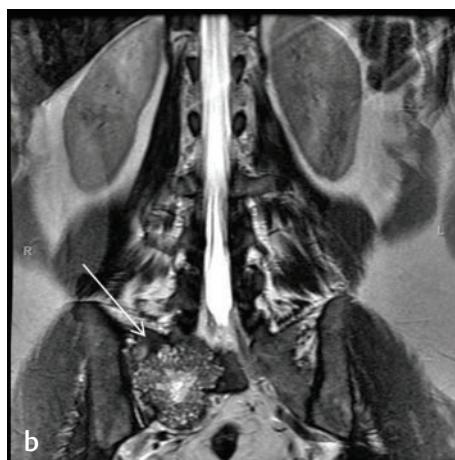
MRI: excellent soft-tissue contrast. (a) This AP radiograph of the lumbar spine was obtained in a young patient for the evaluation of pain. The subtle lytic lesion in the right hemisacrum (*arrows*) can be difficult to differentiate from adjacent bowel loops. (b–d) The patient had a subsequent MRI study that showed a large soft-tissue mass (*arrow on each*) with fluid–fluid levels extending into the presacral tissues and sparing the spinal canal. (e) Axial precontrast and (f) postcontrast T1-weighted images with fat saturation reveal the enhancing soft-tissue component (*arrow on each*).
